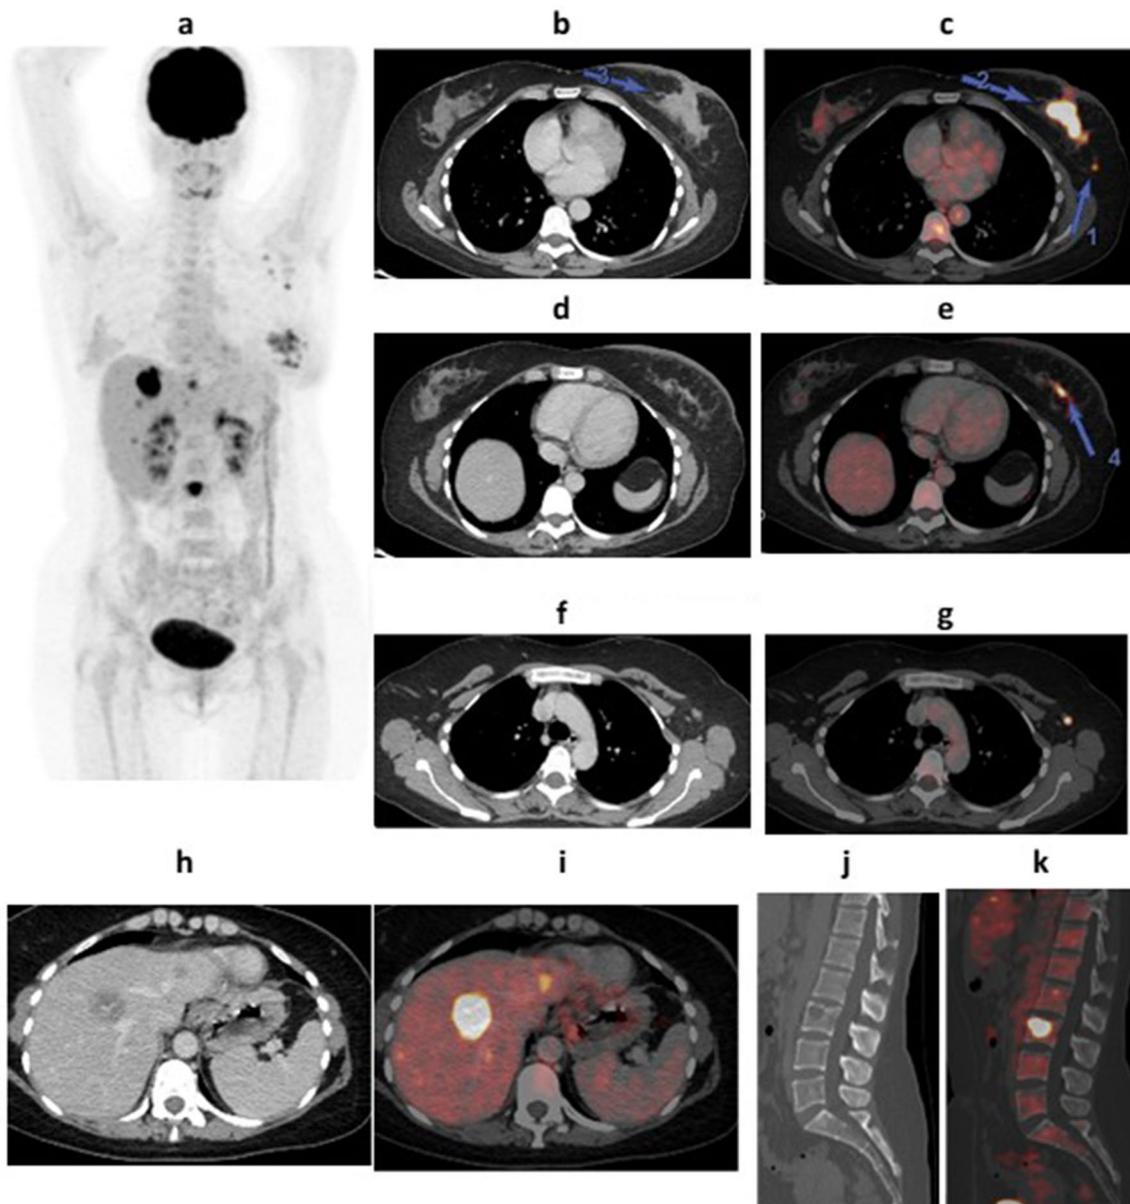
A 37-year-old female patient arrived with newly diagnosed left breast cancer (IDC grade II). a A PET MIP picture of the entire body indicated active left breast, axillary, hepatic, and osseous lesions. b, c, d, e Axial CECT and fused PET/CT images revealed large ill-defined mildly enhancing speculated metabolically active left breast retroareolar soft tissue mass focally infiltrating the overlying nipple with retraction, measuring about $29 \times 39 \times 59$ mm and achieving up to 7.9 SUVmax with other adjacent small metabolically active parenchymal lesions at lower outer quadrant, in fused PET/CT images, measuring up to 10×15 mm and achieving up to 6.6 SUVmax, not appreciated in CT images alone. f, g Axial CECT and fused PET/CT images revealed few variable-sized left axillary lymph nodes, measuring up to 11×21 mm and achieving up to 6.3 SUVmax. h, i Axial CECT and fused PET/CT images revealed bilobar hypodense metabolically active hepatic focal lesions, the largest and most active of them is seen at subsegment IVa, measuring about $29 \times 31 \times 39$ mm and achieving 15.2 SUVmax. j, k Axial CECT and fused PET/CT images revealed hypermetabolic lytic osseous lesion at L3 body, achieving 12 SUVmax
